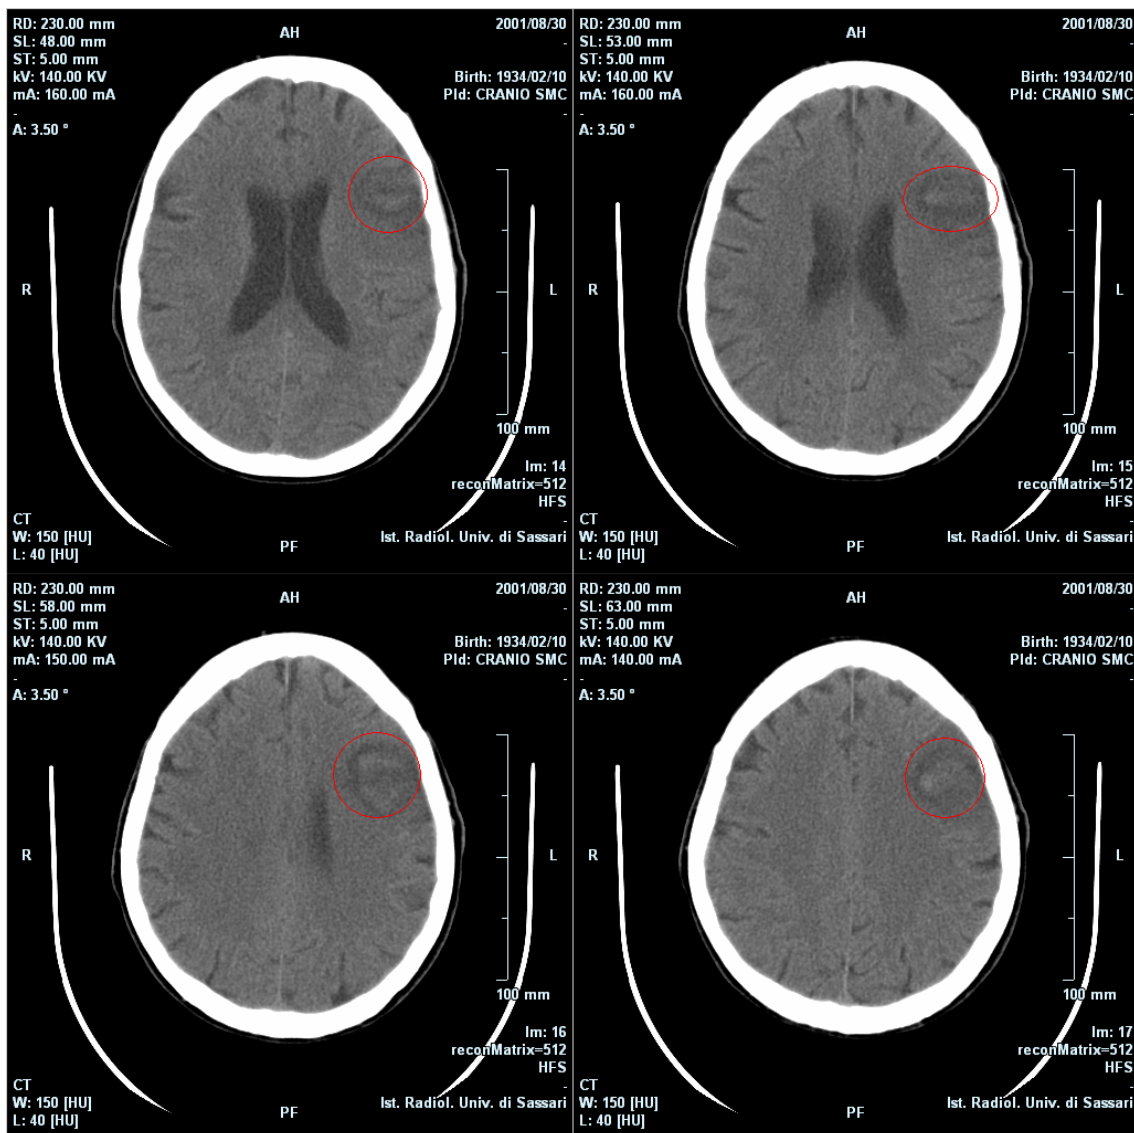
CT scan 30.08.01.
